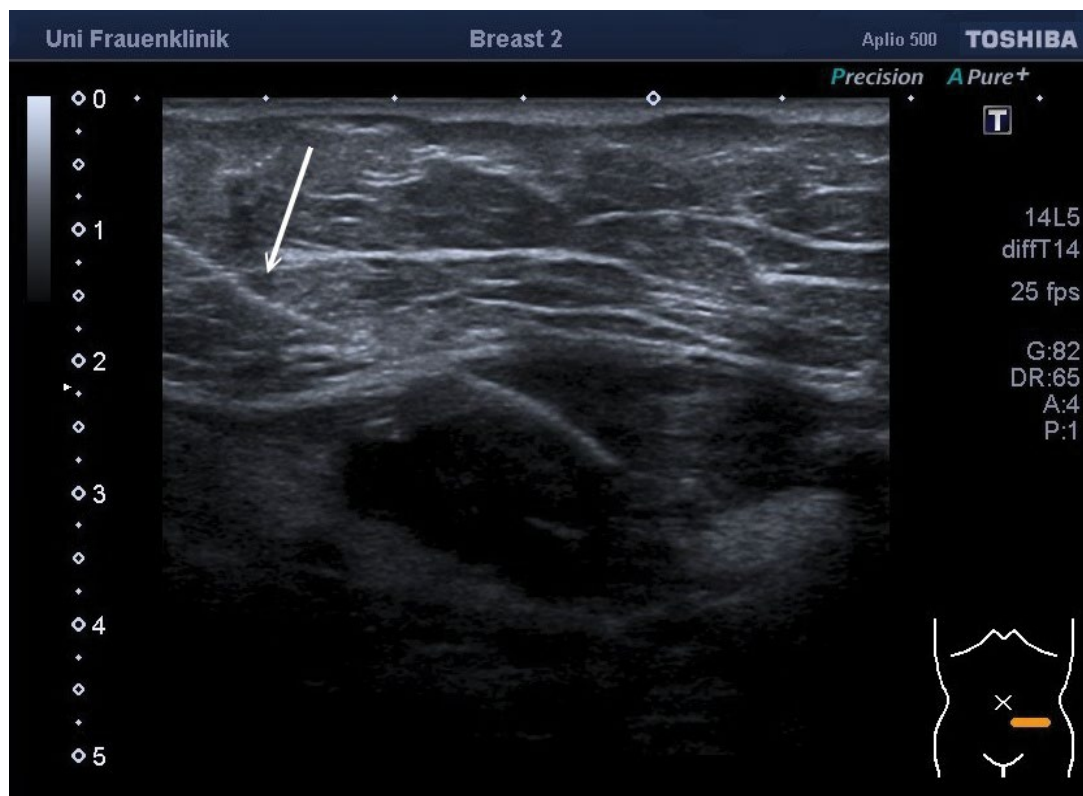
Preoperative ultrasound-guided wire marking (2D, Aplio 500, 13 MHz (Toshiba™)).
